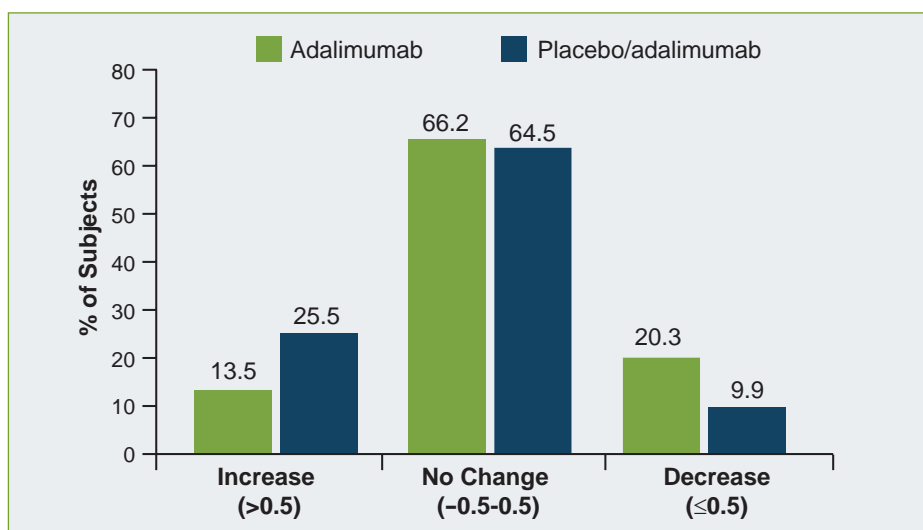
Adalimumab and inhibition of disease progression. Lack of radiographic progression as indicated by changes in Sharp score of -0.5 to 0.5 units was documented in a majority of subjects (66.2%) who received adalimumab ($n = 133$) over 48 weeks, as well as those who initially received placebo then switched to adalimumab ($n = 141$). As indicated by an increase in Sharp score of at least 0.5 units, radiographic progression was demonstrated in 13.5% of those who received adalimumab monotherapy for the duration of the study vs 25.5% of those who initially received placebo. Gladman DD et al.²⁸
